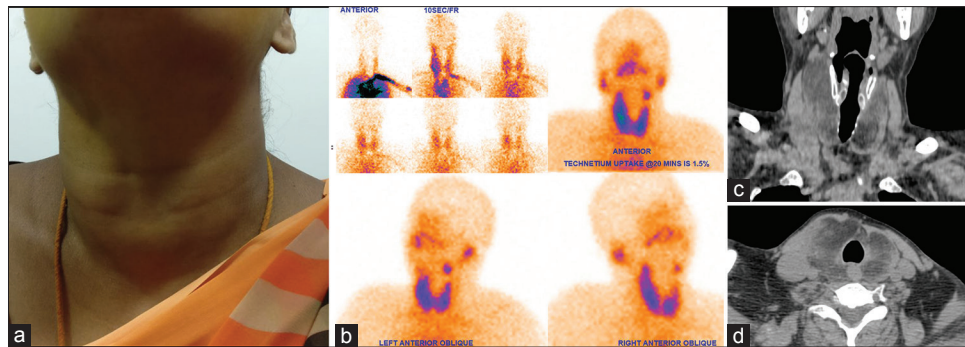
A 49-year-old female presented with diffuse and soft neck swelling (a). The lower border of the swelling was not well made out. She underwent technetium TS as per the standard protocol (b). Technetium thyroid scan showed physiological perfusion and trapping function in both lobes of thyroid without any obvious cold nodules. Noncontrast computed tomography performed for the evaluation of retrosternal extension and tracheal status [(c) coronal; (d) transaxial sections) showed diffuse fatty infiltration (60 HU) with thyroid stroma showing higher attenuation
